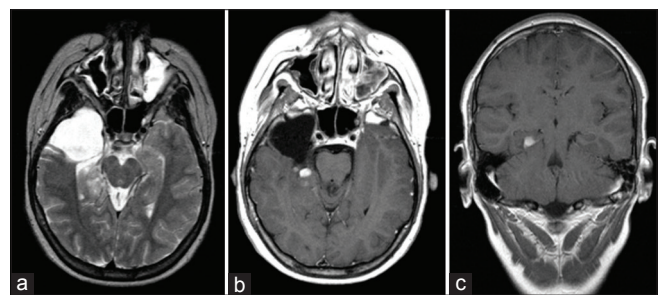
(a-c) 2001 axial T2, axial and coronal CET1 MR images post subtotal resection demonstrate residual contrast enhancing DNT
